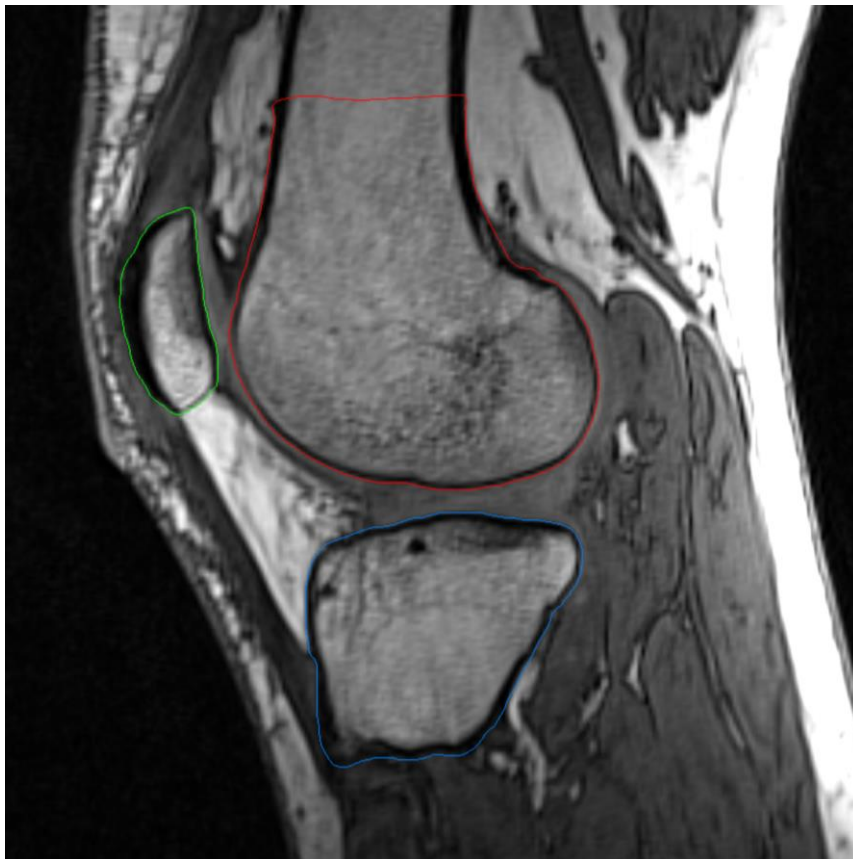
(i) Acromegaly vibe image, lateral condyle, sagittal. Bone edges are well visualized, however cartilage edges and meniscus are not well visualized in the tibiofemoral joint (arrow). (ii) Dual-echo at steady-state water-excitation (DESS-we) fat saturated image, lateral condyle, sagittal. Most of previously published work from Imorphics has used this sequence of MR images, with fat signal remover. Cartilage edges and meniscus are well visualized in the tibiofemoral joint (arrow), allowing for accurate measurement.
